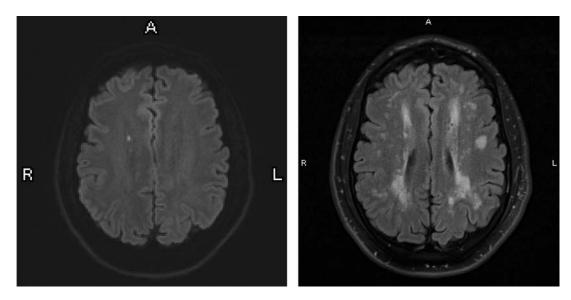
Magnetic resonance imaging of the brain transeverse section, with diffusion weighted imaging (left) and T2 flair (right). Imaging revealed an acute lacunar infarct in the right corona radiata, while T2/fluid-attenuated inversion recovery sequences revealed signal hyperintensity in the subcortical greater than periventricular white matter. Extensive dural calcifications were also noted as atypical for the patient's age.
